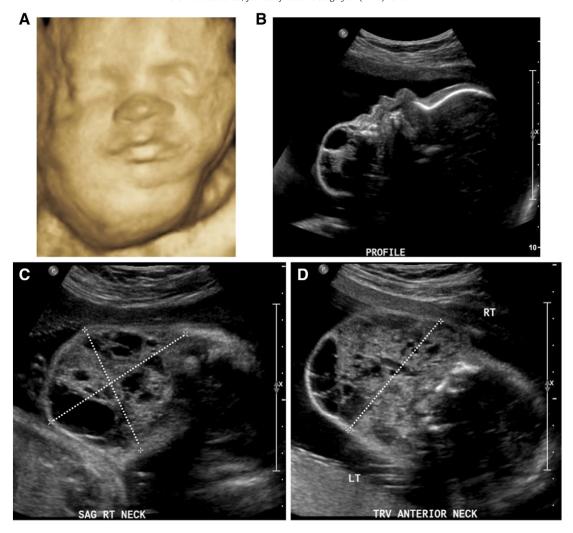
Sonographic evaluation and measurement of LMs. U/S evaluation of a 27 week fetus with a large cervical LM depicted following 3 dimensional reconstruction (A) and in the profile view (B). The volume of the LM is calculated using the formula for the volume of a prolate ellipse after obtaining the maximum length, height, and width measurements in the sagittal and transverse views (volume  $= L \times H \times W \times 0.52$ ) (C & D). The LM volume ratio (LVR) is subsequently calculated by dividing the LM volume by the HC to normalize for gestational age. The depicted fetus had an HC of 25 cm and an LM volume of 84 mL (5 cm  $\times$  5.4 cm  $\times$  6 cm  $\times$  0.52) resulting in an LVR of 3.4.
